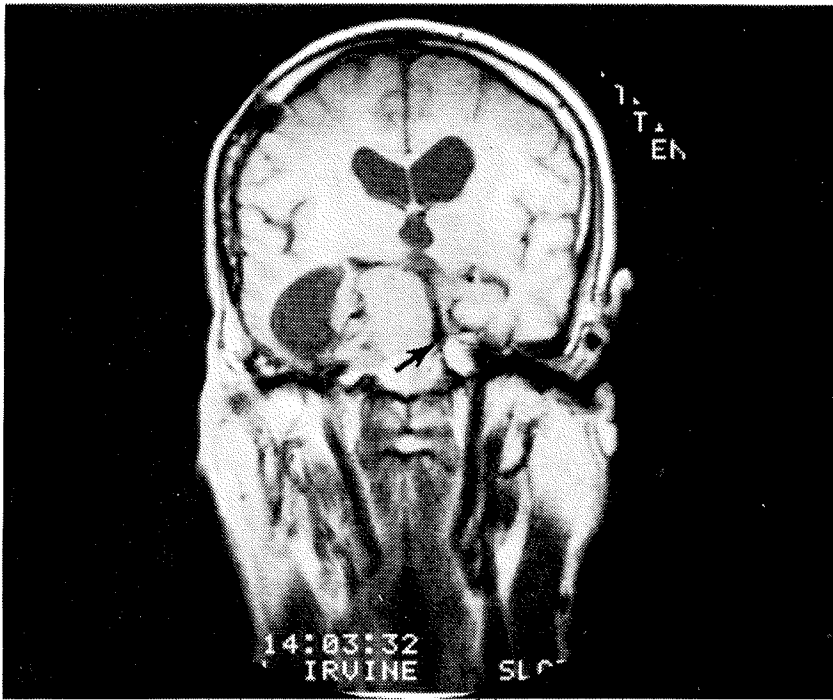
Clivus Meningioma. Coronal MR image shows tumour displacing basilar artery (arrow).
